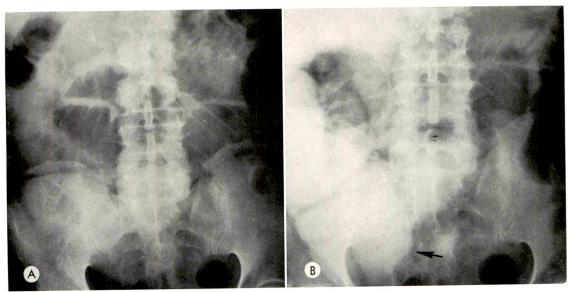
Adynamic ileus. A 69 year old man developed distention, pain and hypoactive bowel sounds 9 days postoperatively (suprapubic prostatectomy). (A) Survey roentgenogram shows distention mainly of the small bowel loops. (B) Hypaque passed to the cecum in 2 hours (arrow). The above roentgenogram was taken at 6 hours. A diagnosis of adynamic ileus was made. Tube decompression was effective in 36 hours.
